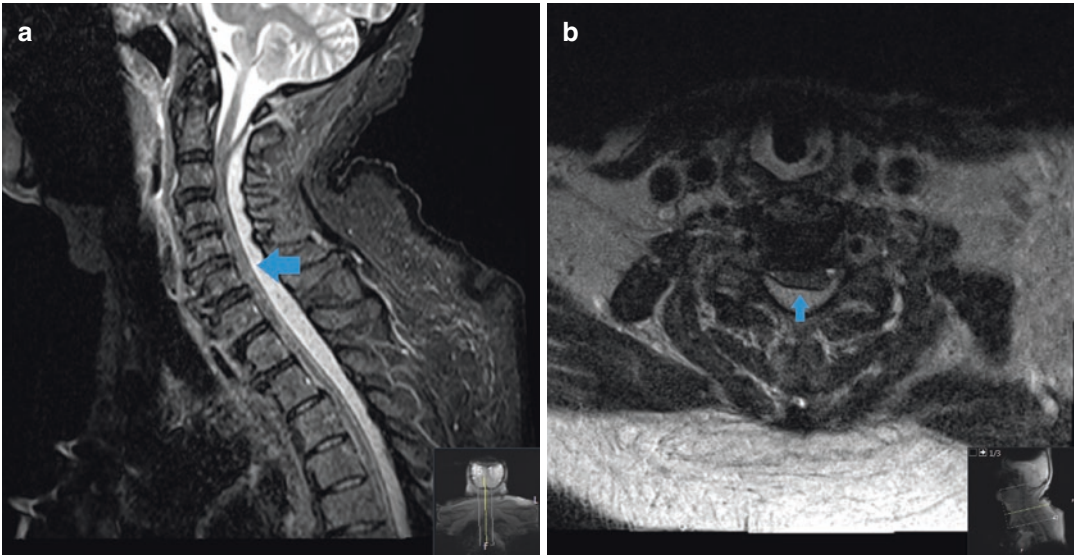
Epidural abscess Figure 9.4a is a sagittal fat-saturated T2-weighted MR image showing a large dorsal epidural collection causing mass effect on the cervical cord (arrow). In Fig. 9.4b, an axial T2-weighted MR
